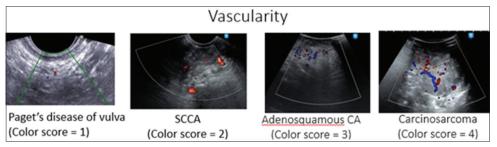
Doppler studies of different vulvar cancer types
